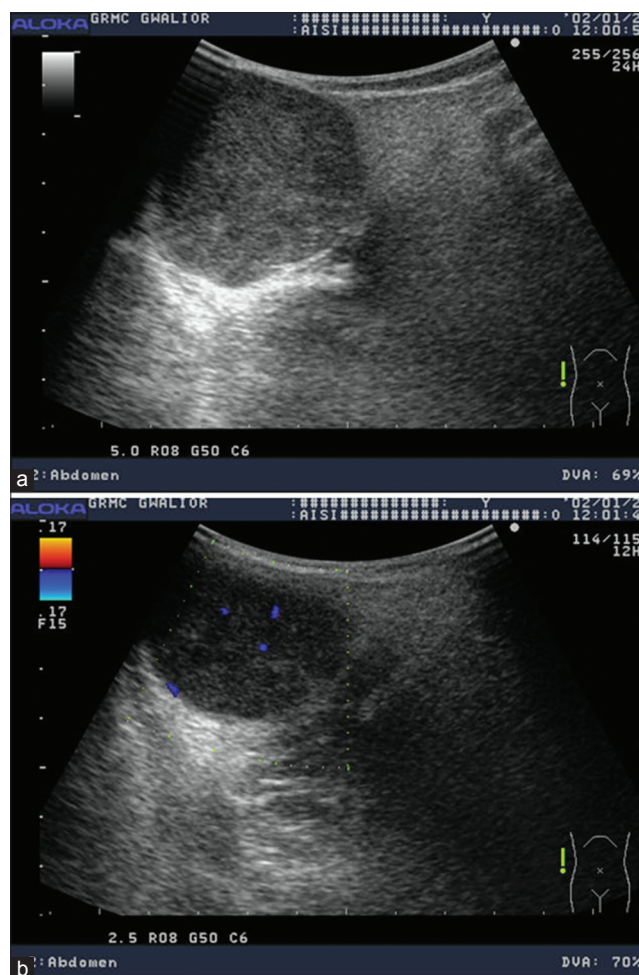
(a and b) Grayscale and color Doppler ultrasonography image of pleomorphic adenoma of right parotid gland
